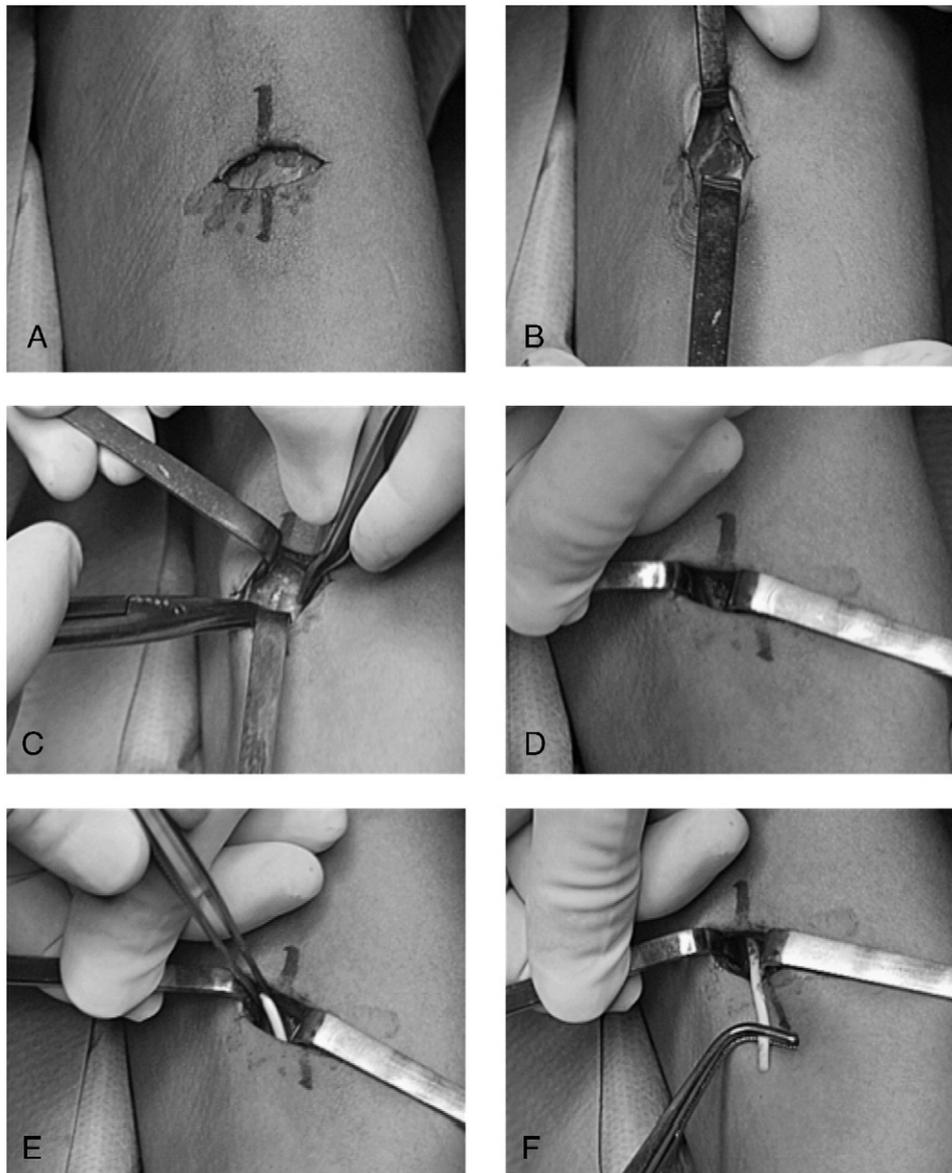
Removal of an intramuscularly positioned implant near the brachial plexus. (A) The implant was identified by ultrasound, and the skin was marked. After transverse skin incision across the implant, the aponeurosis was exposed. (B) Muscular exposure after aponeurosis incision. (C) Identification of the brachial plexus. (D) The implant was more lateral, in an intramuscular position. (E and F) Removal of the implant.
